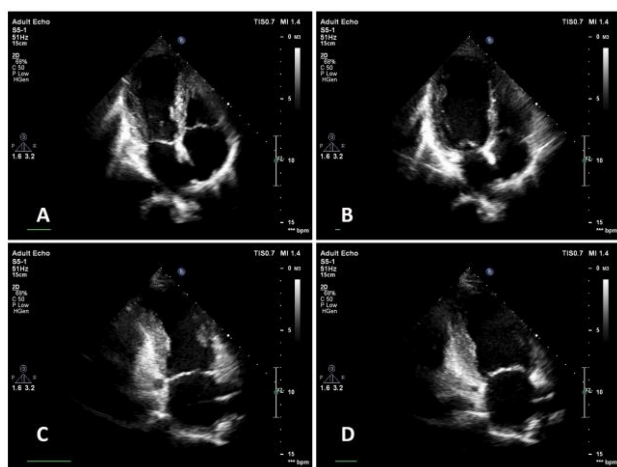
Transthoracic echocardiography, apical view A) 4 chamber, left ventricular apex aneurysmatic basal segment hyperkinetic, B) 4 chamber, normalized, C) 2 chamber, left ventricular apex aneurysmatic basal segment hyperkinetic, D) 2 chamber, normalized
